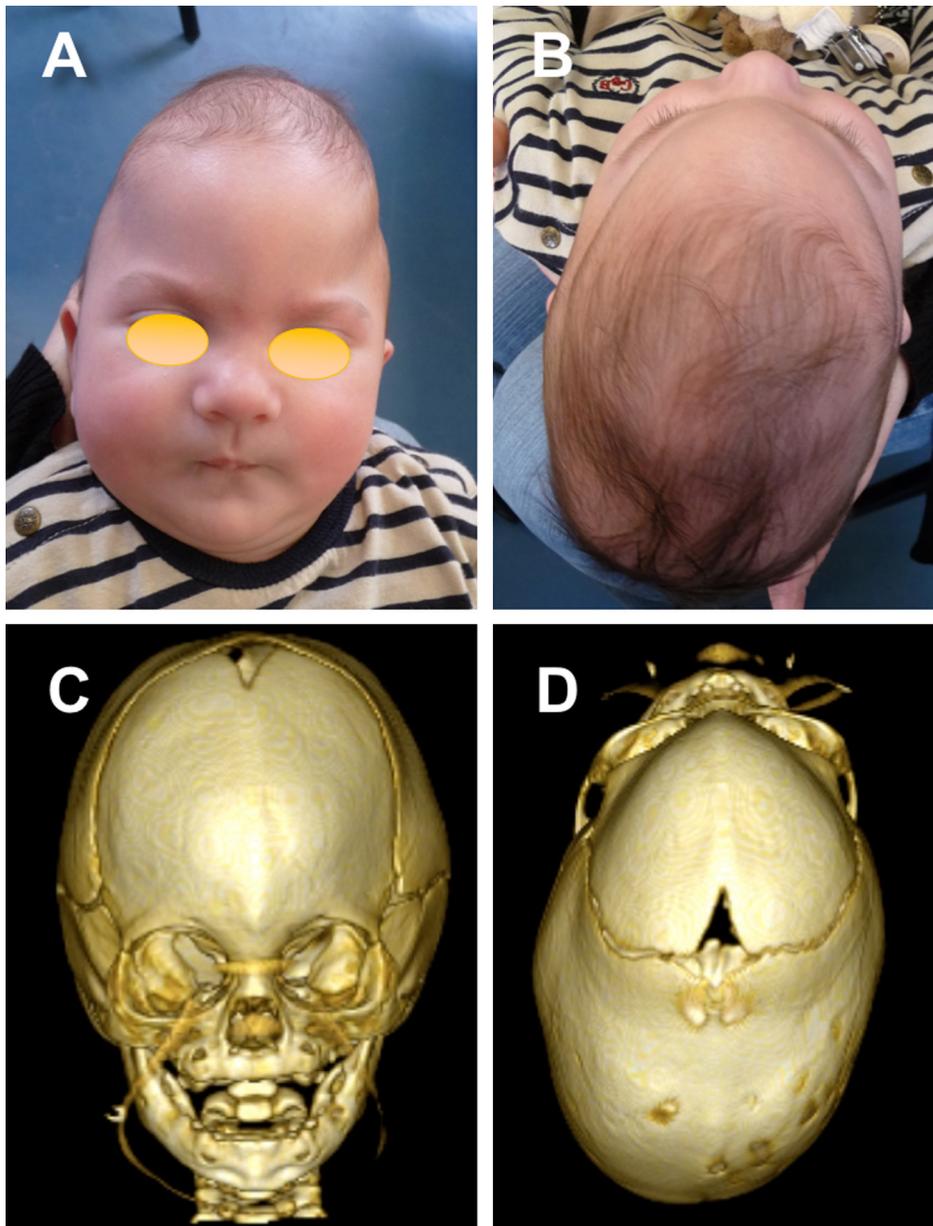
Male child with leptocranium (combined synostosis of the metopic and sagittal sutures). A and B. The child seen aged 3 months; C and D: CT scan at 3 months.
